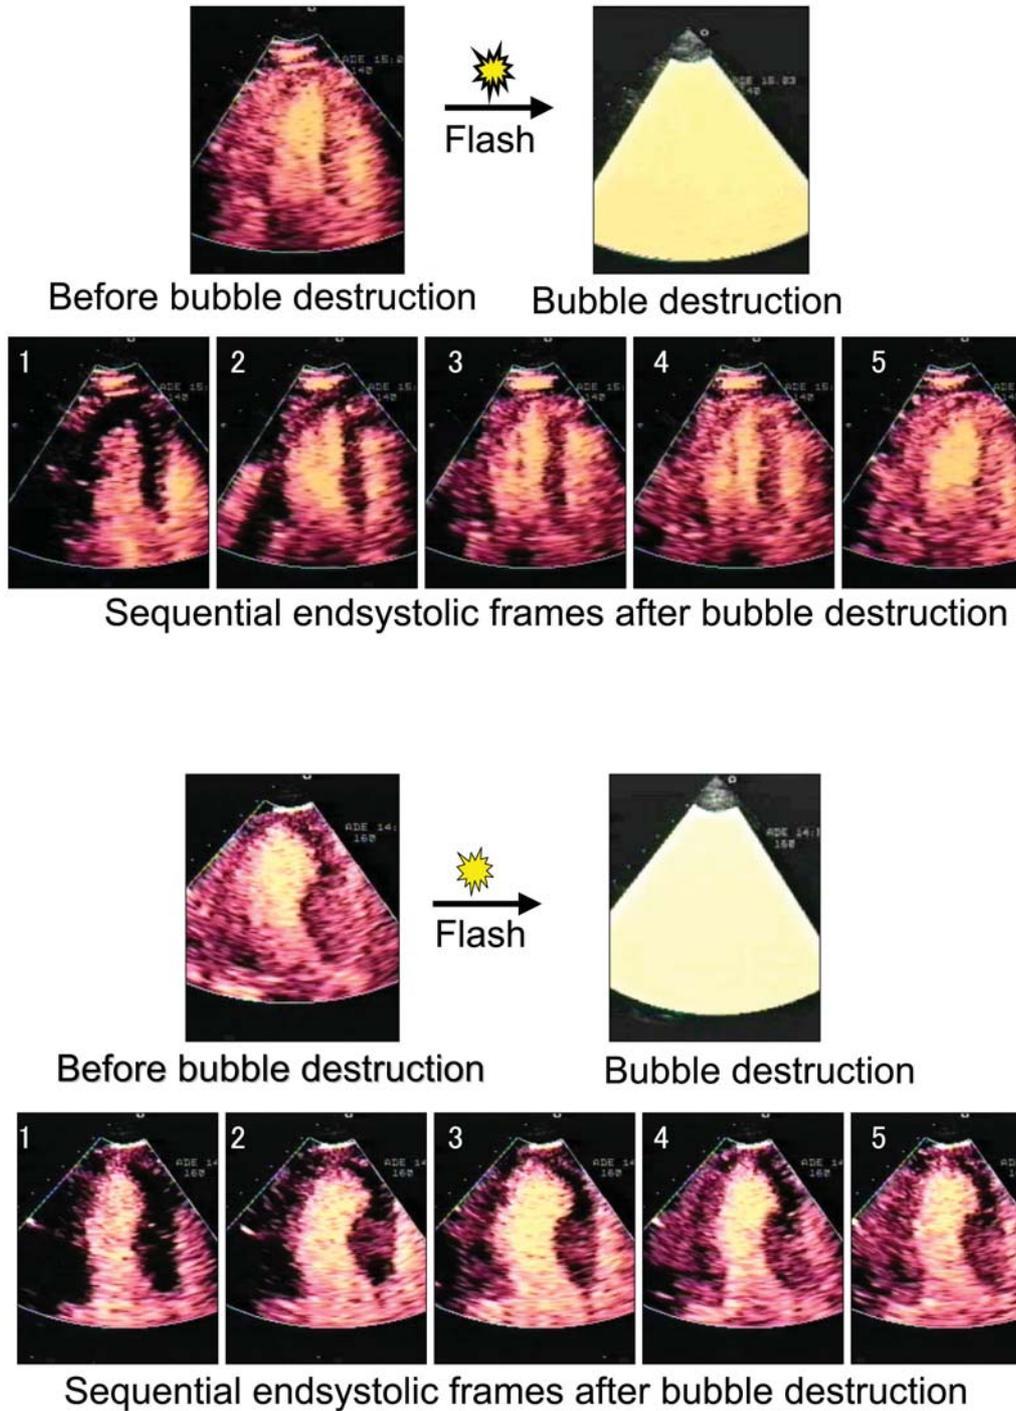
After destruction by high acoustic power ultrasound pulses, gradual replenishment of microbubbles within the LV myocardial microvasculatures is displayed at sequential endsystolic frames. In a normal subject, homogeneous refilling of microbubbles is completed at the 5th endsystolic frame. In a patient with left anterior descending artery (LAD) stenosis, incomplete refilling in the LAD territory is evident at the 5th endsystolic frame.
